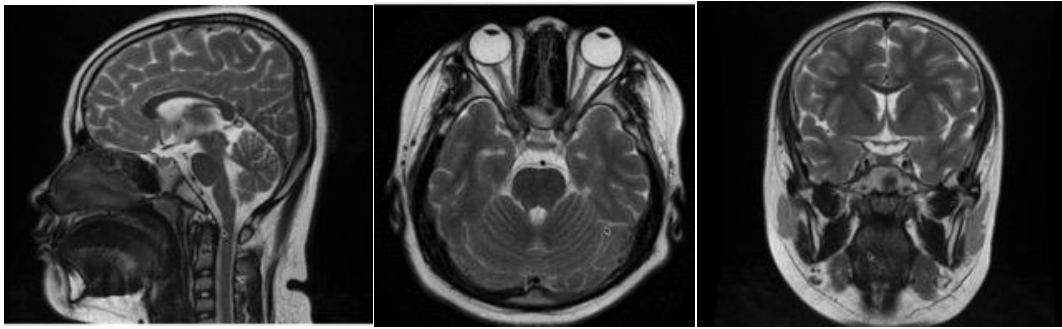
Brain and orbit MRI showed no optic nerve enhancement, mass, nor aneurysm
